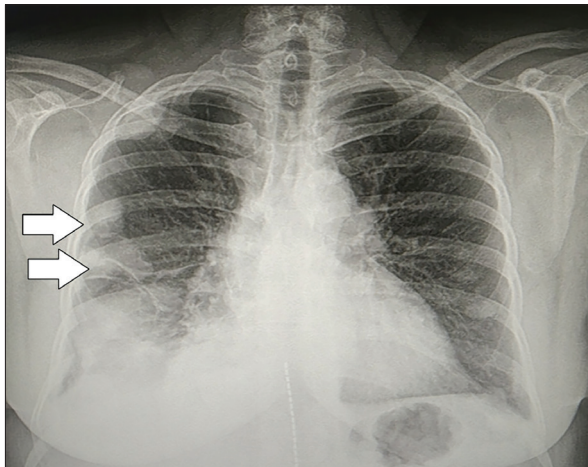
Chest X-ray showing multiple lung nodules in the right middle lobe.
